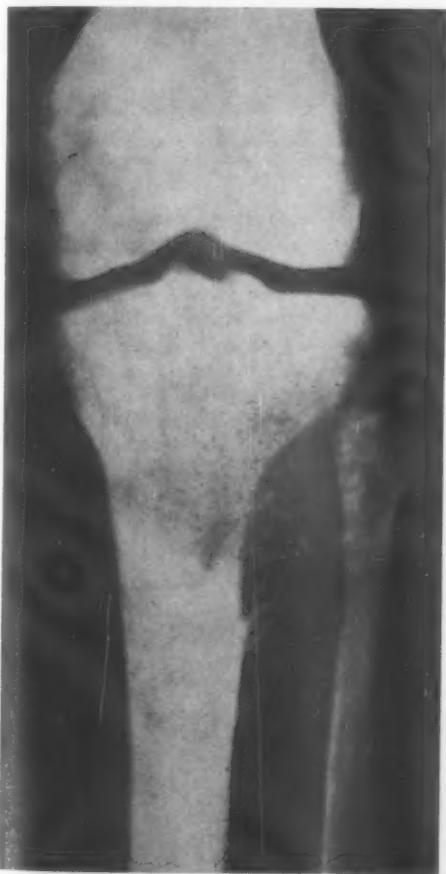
X-ray showing the tumour of the upper part of the tibia. There is rarefaction of the bone and a soft tissue mass, between the tibia and fibula, showing spicules of calcified material.
